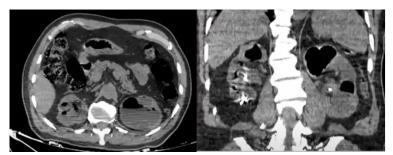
Abdominal CT scan in axial (A) and coronal (B) sections showing: Bilateral renal intraparenchymal gas bubble with appearance of right upper polar pyelonephritis in a 53-year-old female patient with type 2 diabetes
